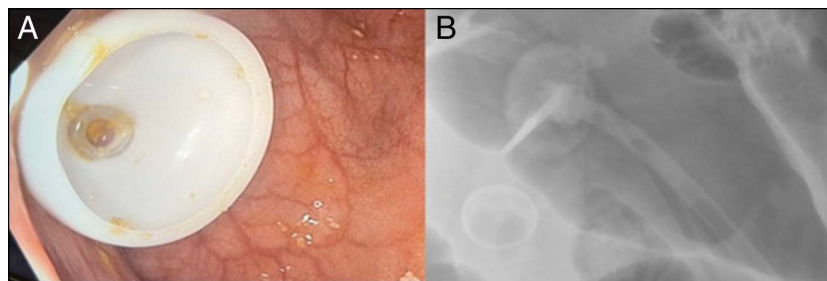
Successful placement of the percutaneous endoscopic colostomy tube endoscopically (A) and radiographically (B) visualized.
